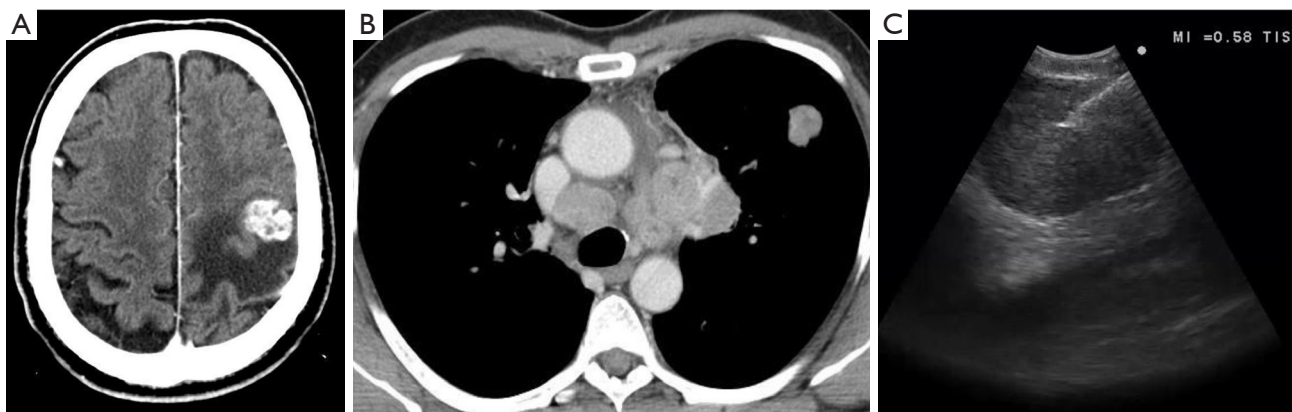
“Mediastinal diagnosis” through endosonography in a patient with stage IV (brain mets). (A) Left parietal brain metastasis (clinical stage IV disease); (B) enlarged mediastinal lymph nodes are evident in stations #4R, #4L, #5, #10L; (C) EBUS-TBNA from the #4R lymph node. EBUS-TBNA, endobronchial ultrasound-guided transbronchial needle aspiration.
